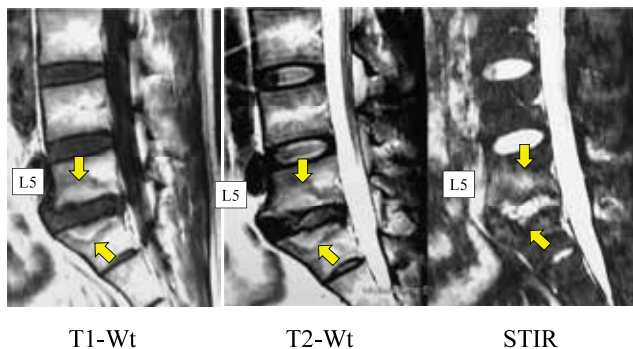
MRI at initial presentation
